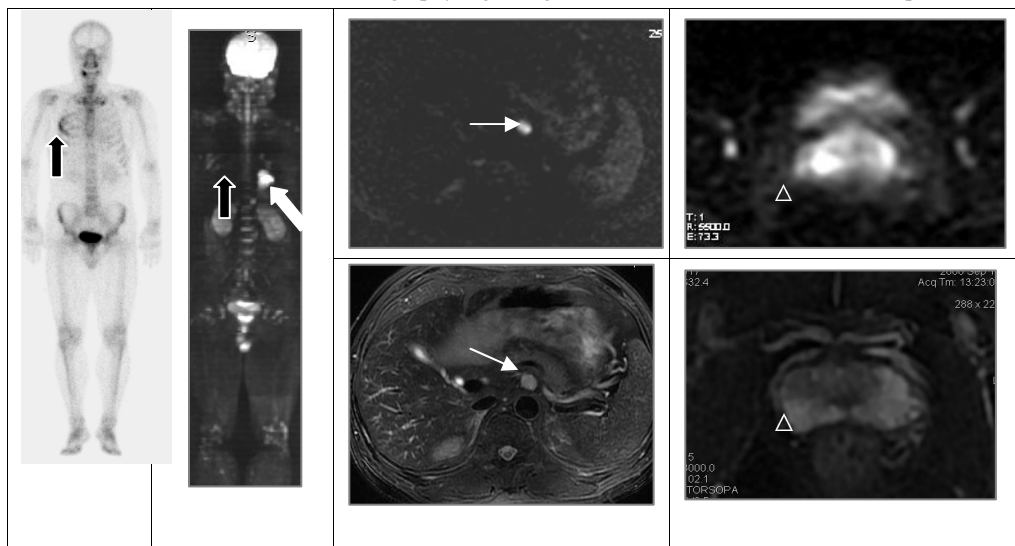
A 53 years old male patient with lung carcinoma (white arrow). Scintigraphy detected multiple metastases in ribs (black arrow) which were also detected by whole body DWI. Besides, whole –body DWI detected the retroperitoneal metastatic lymph nodes (arrow) and abnormality in the prostate (triangle) which were identified by T2WI.
